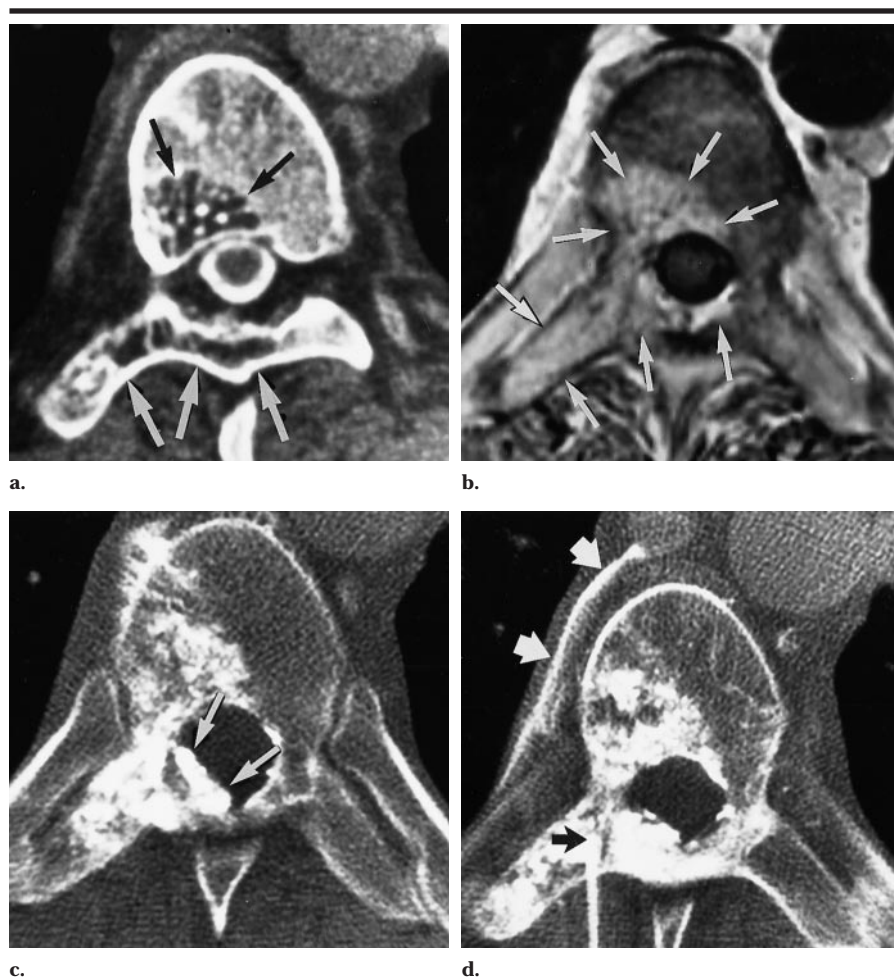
Patient 8. Right T7 radiculopathy and hemangioma involving the right body, pedicle, and lamina of T7 in a 41-year-old man. Note the absence of invasion of the spinal canal by the hemangioma (arrows) on both the (a) transverse CT myelogram and (b) transverse gadolinium-enhanced spin-echo intermediate-weighted MR image (1,000/15). (c) Transverse CT angiogram shows hemangiomatous involvement of the right pedicle and lamina with a posterolateral intracanalicular component (arrows). (d) Transverse CT scan of the hemangioma shows placement of the needle (black arrow) at the junction of the pedicle and lamina with filling of all components of the hemangioma. Note filling of a right intercostal vein (white arrows), which indicates that less than 10 mL of ethanol will be adequate. Subsequent injection of 3 mL of ethanol obliterated the malformation.
